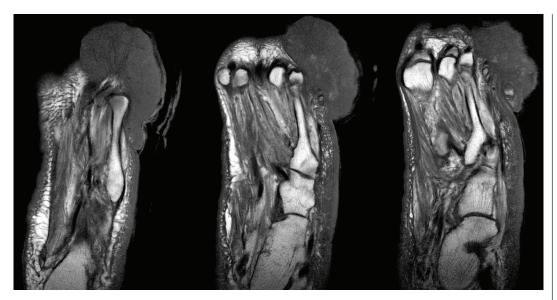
A T1-weighted MRI scan noted that the lesion was predominantly superficial, tracking superficial to the subcutaneous fat in continuity with the dermis, except at the most lateral aspect of the foot where it extended through the subcutaneous fat abutting the head of the fifth metatarsal.
